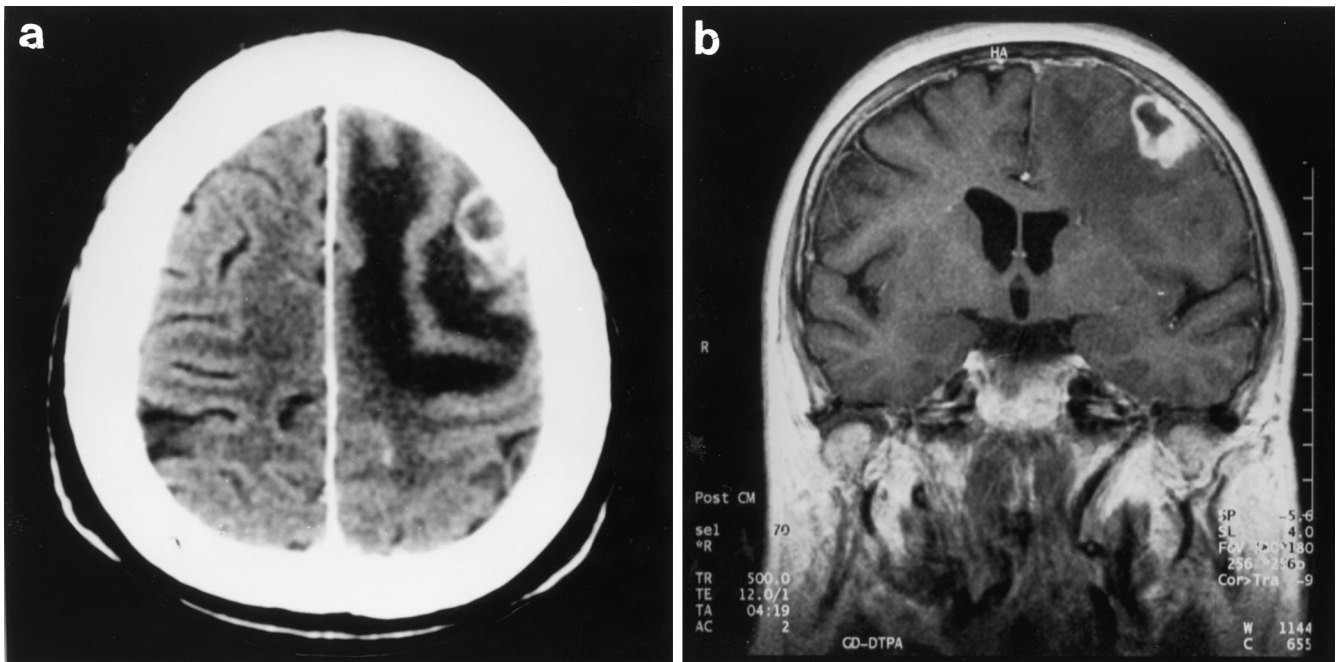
a, b Radiographic findings. a Contrast-enhanced computed tomography scan showing a left fronto-parietal cortical mass with solid, cystic, and necrotic areas. Contrast enhancement was particularly prominent at the tumor margins. b Contrast-enhanced T1-weighted cranial magnetic resonance imaging of the fronto-parietal cortical mass lesion
